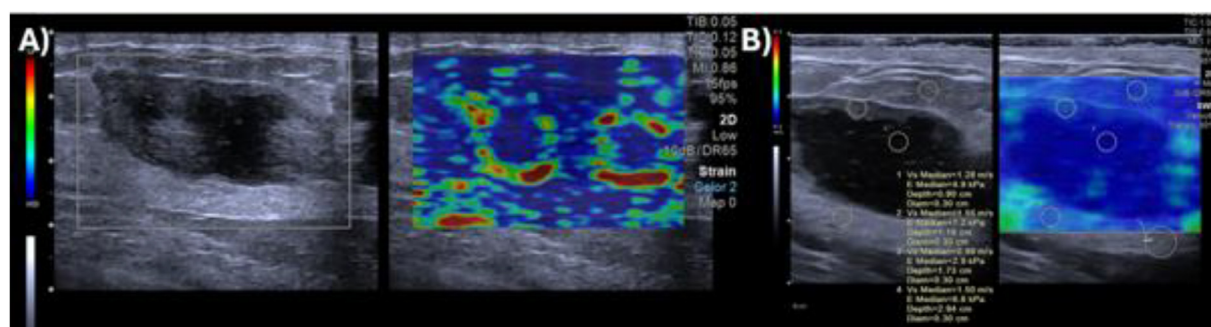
Ultrasound elastography. (A) Strain elastography showed BGR pattern. (B) Shear wave elastography showed normal reading of the thickened wall which as 7.2kPa.
